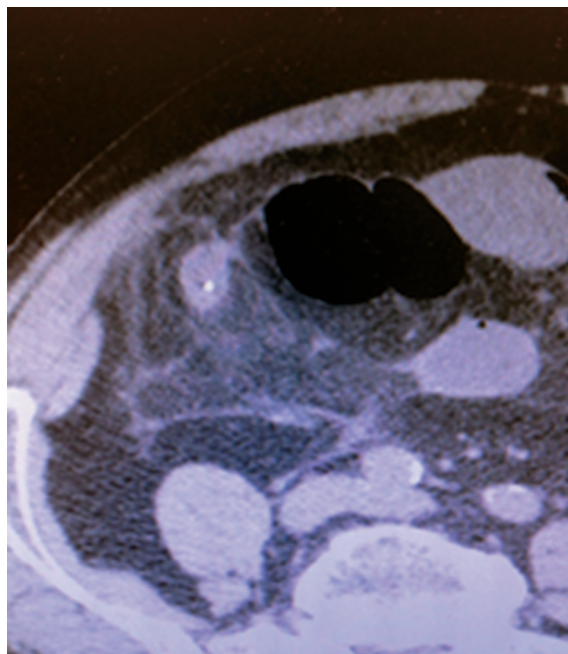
Abdominal CT scan showing a bullet into the appendiceal lumen.
